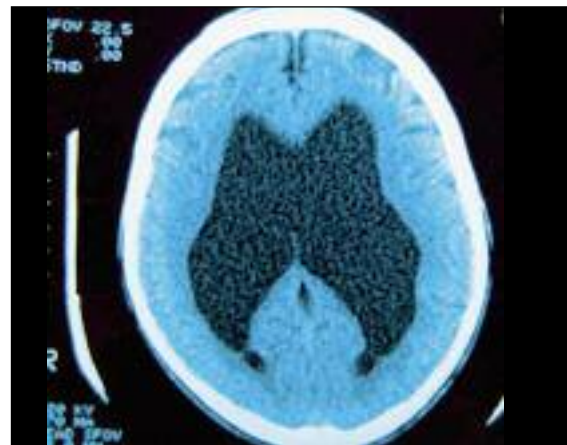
CT scan of brain.
